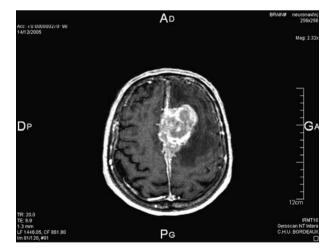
Frontal homogeneous mass presenting as a meningioma (T1-weighted sequences after IV Gadolinium infusion)
